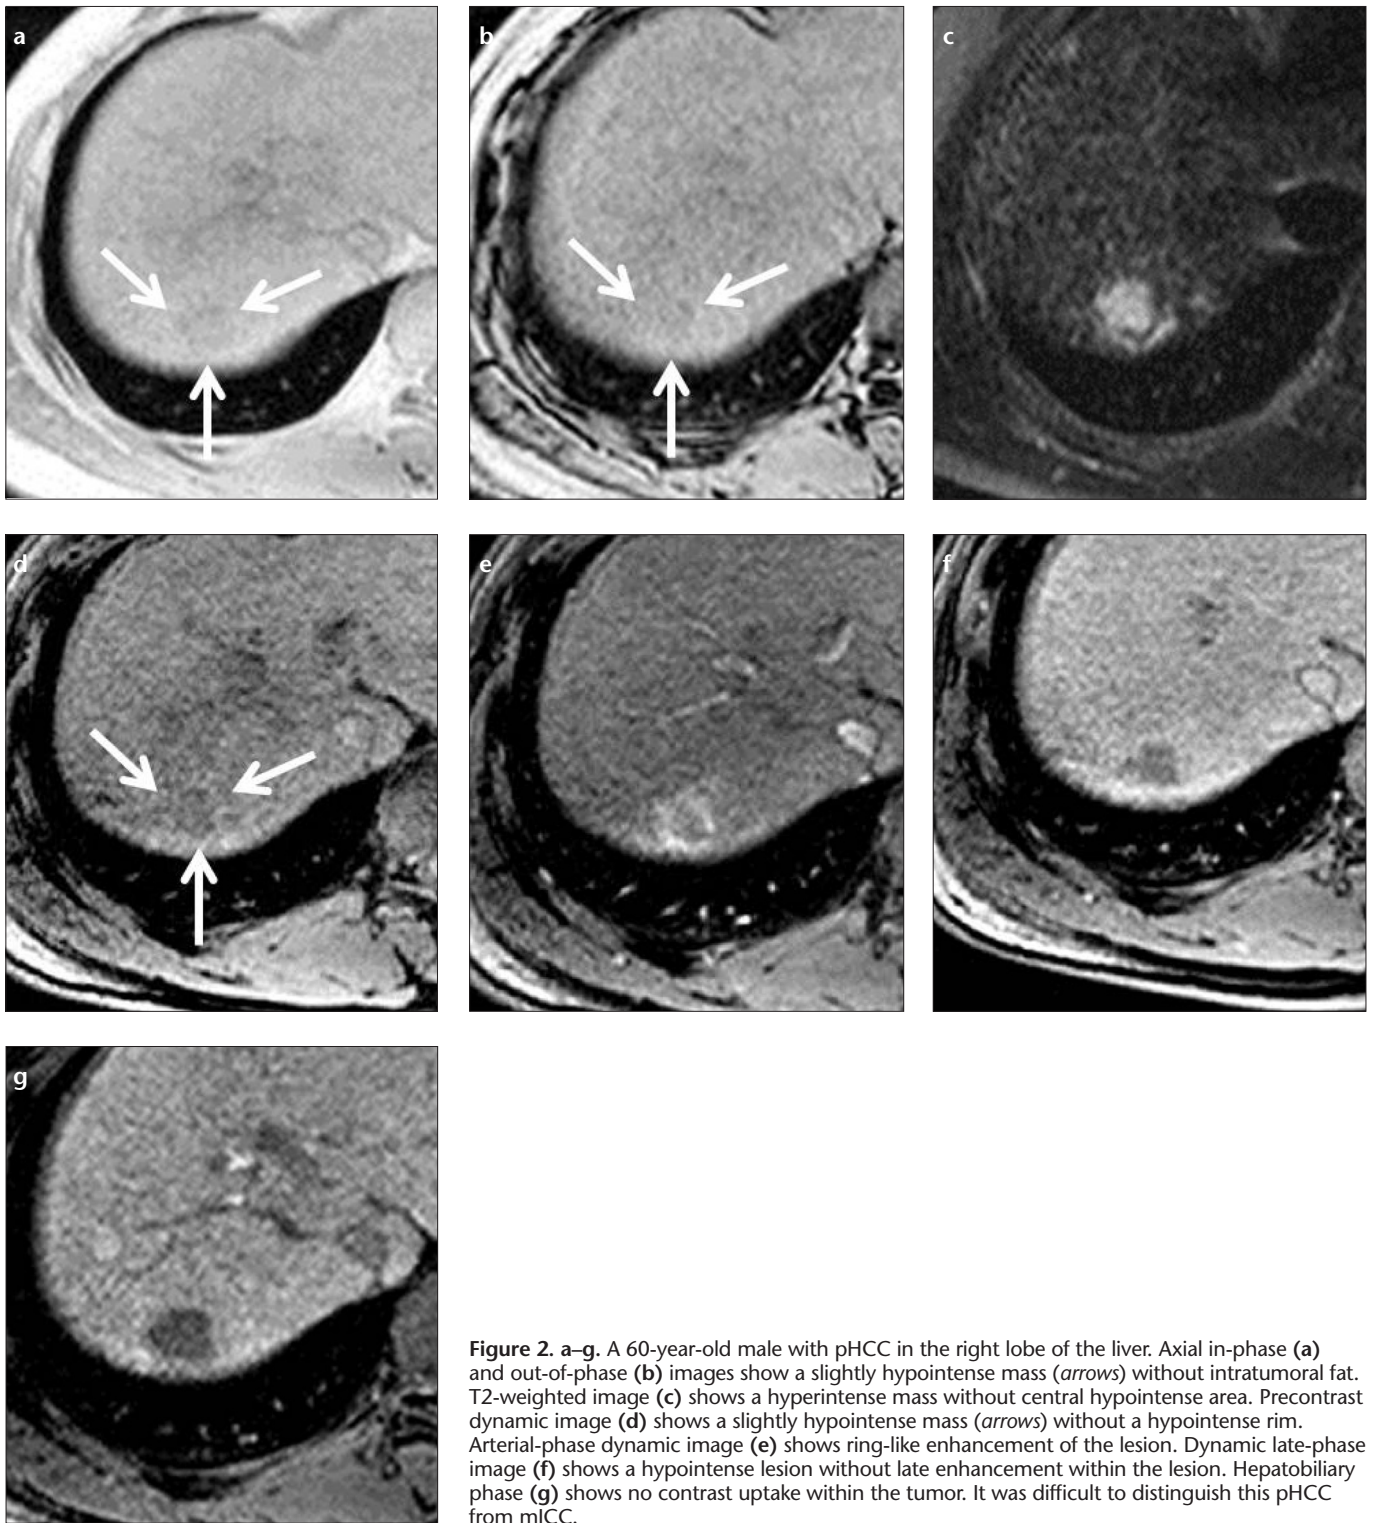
a-g. A 60-year-old male with pHCC in the right lobe of the liver. Axial in-phase (a) and out-of-phase (b) images show a slightly hypointense mass (arrows) without intratumoral fat. T2-weighted image (c) shows a hyperintense mass without central hypointense area. Precontrast dynamic image (d) shows a slightly hypointense mass (arrows) without a hypointense rim. Arterial-phase dynamic image (e) shows ring-like enhancement of the lesion. Dynamic late-phase image (f) shows a hypointense lesion without late enhancement within the lesion. Hepatobiliary phase (g) shows no contrast uptake within the tumor. It was difficult to distinguish this pHCC from mICC.
